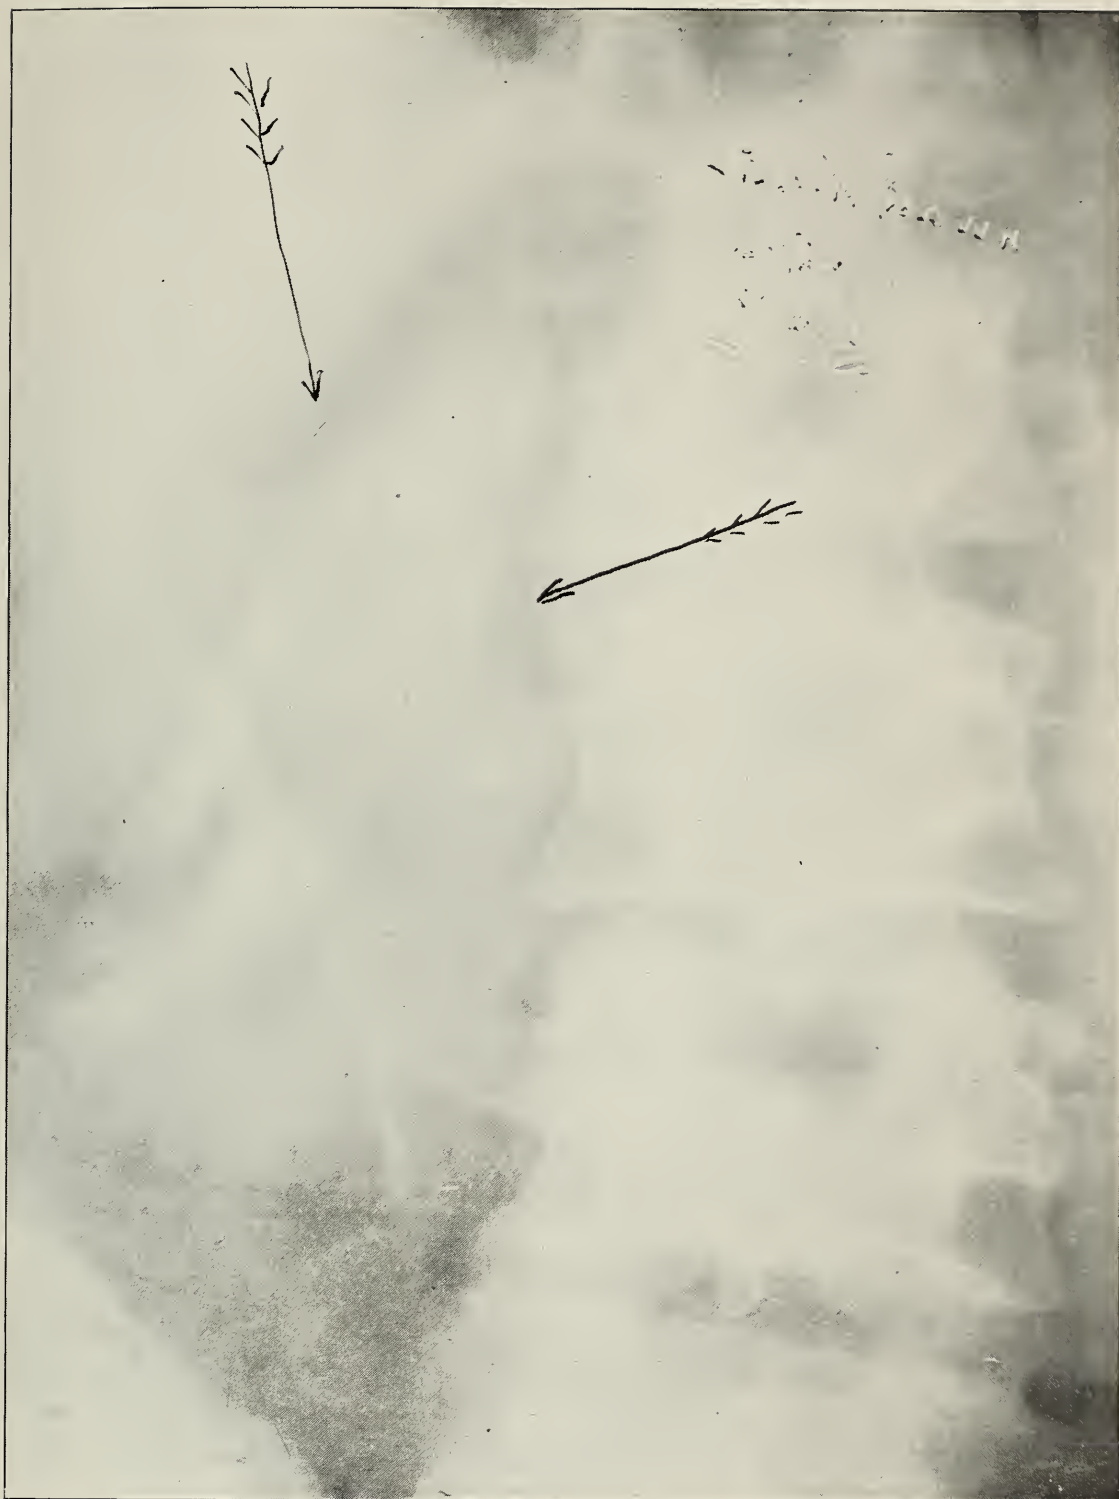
X-ray No. 8517. Region: right lumbar. Colloidal silver injection of renal pelvis. Original plate showed a shadow size of a pigeon's egg over region of right renal pelvis. Arrows point to shadow overlapping renal pelvis. No evidence of obstruction or dilatation. At operation proved to be a large gall-stone covered with a deposit of lime salts.
